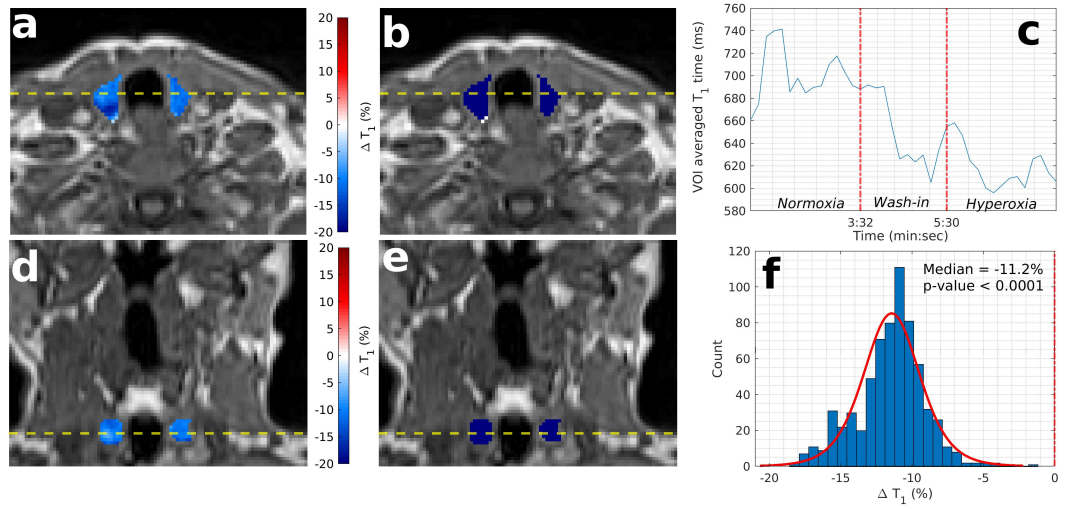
Parametric maps from thyroid gland - Example OE-MRI parametric maps of thyroid gland (patient P5). T_1 weighted VIBE image with overlaid parametric ΔT_1 map of the thyroid gland (a, d, axial and coronal plane respectively) and overlaid statistical map of ΔT_1 times (b, e). Blue colour indicates statistically significant decrease in T_1 times, white indicating no statistically significant change and red indicating statistically significant increasing T_1 times. c Time series of T_1 times averaged over the entire thyroid VOI. f Histogram of ΔT_1 times for the entire malignant nodal VOI.
